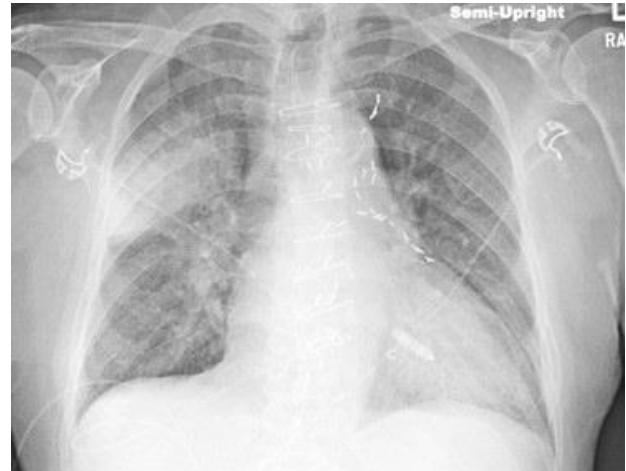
Initial portable chest x-ray.
